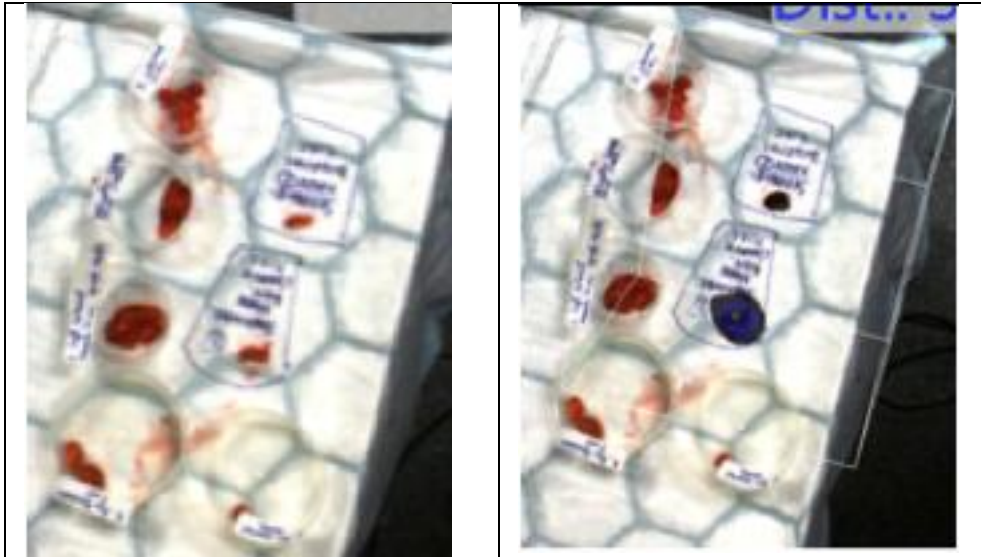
A. Pelvic node dissection packets divided by anatomical region, sentinel nodes were dissected separately and shown in the two squared outlines. B same tissue viewed by fhSPECT showing both sentinel nodes have radioactivity (blue). No other nodes were hot.
